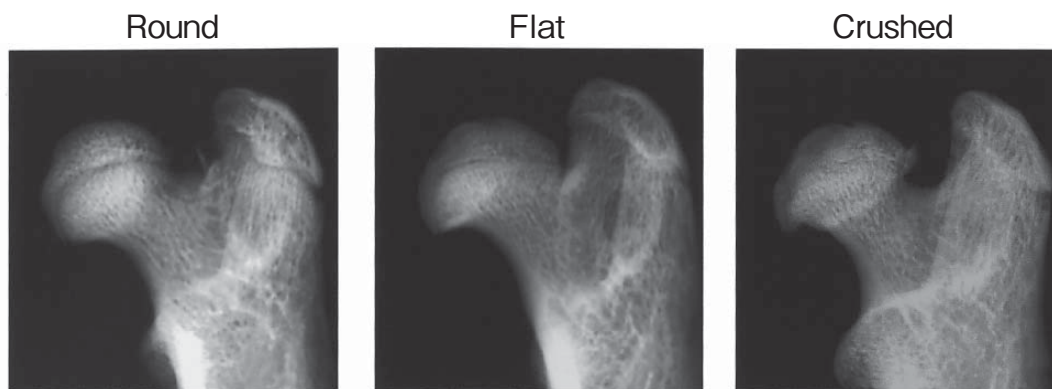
Radiographic appearances of the femoral heads of SHR (Softex). Femoral heads were divided into 3 types: Round, Flat, Crushed.
